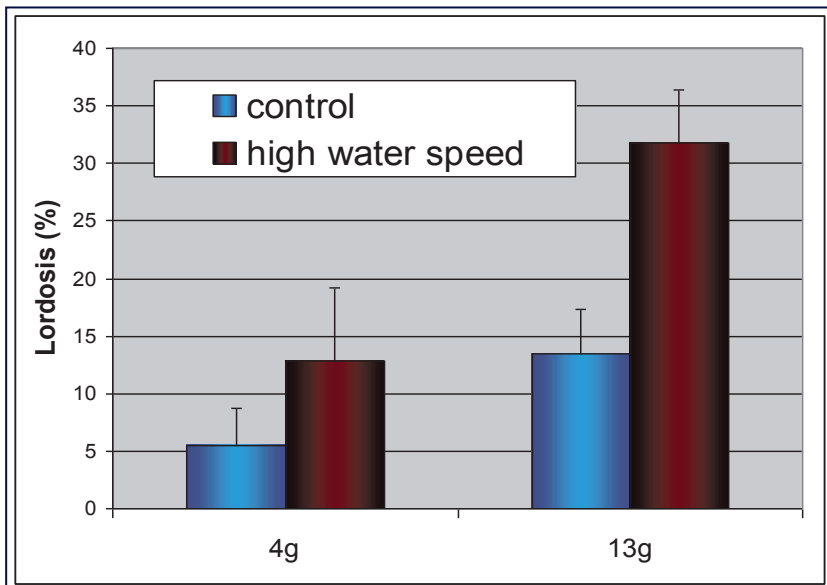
Incidence of lordosis in Atlantic cod (*Gadus morhua*) at 4 and 13 grams size (radiographic evaluation) reared with low water speed (control) or high water speed.
